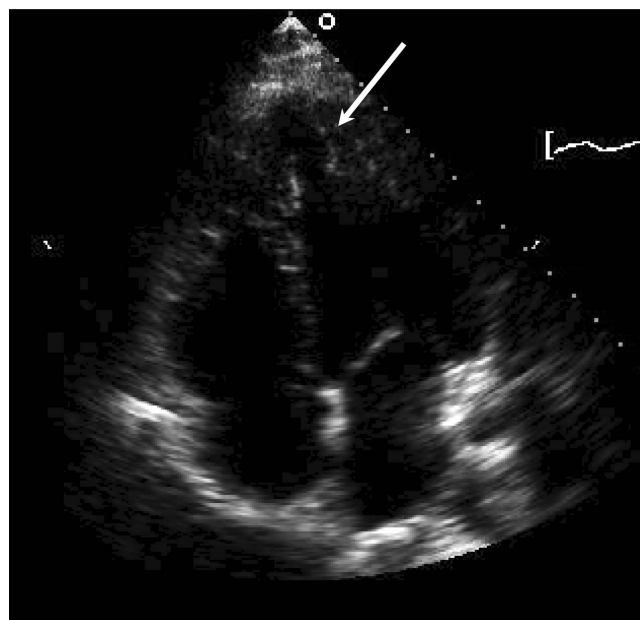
Two-dimensional echocardiographic four-chamber view of the 35-year-old asymptomatic sister of the proband of family A, showing excessive trabeculations of the apical (arrow) and mid-lateral left ventricular walls and mild left ventricular systolic dysfunction. The right ventricle was also excessively trabeculated.
